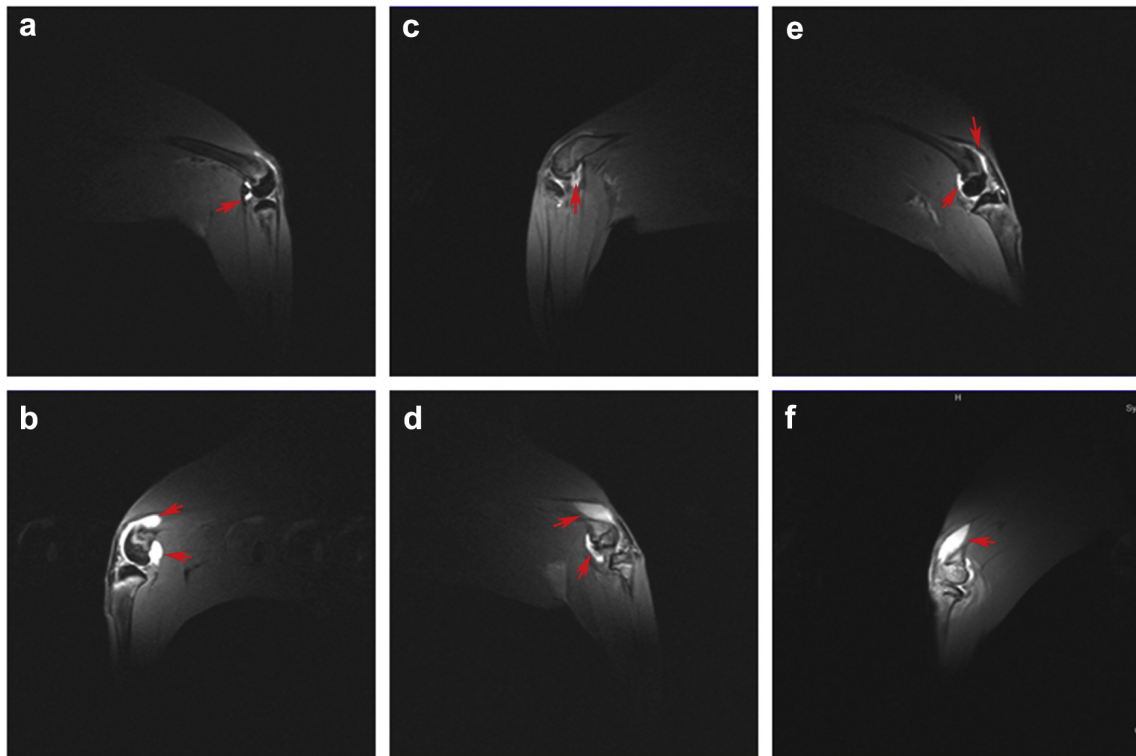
Knee effusion volume in all groups; *red arrows* indicate joint effusion. (a) FLIPUS intervention at 2 wk; (b) Sham intervention at 2 wk; (c) FLIPUS intervention at 4 wk; (d) Sham intervention at 4 wk; e: FLIPUS intervention at 8 wk; f: Sham intervention at 8 wk ($n = 10$ knees each). FLIPUS = focused low-intensity pulsed ultrasound.
